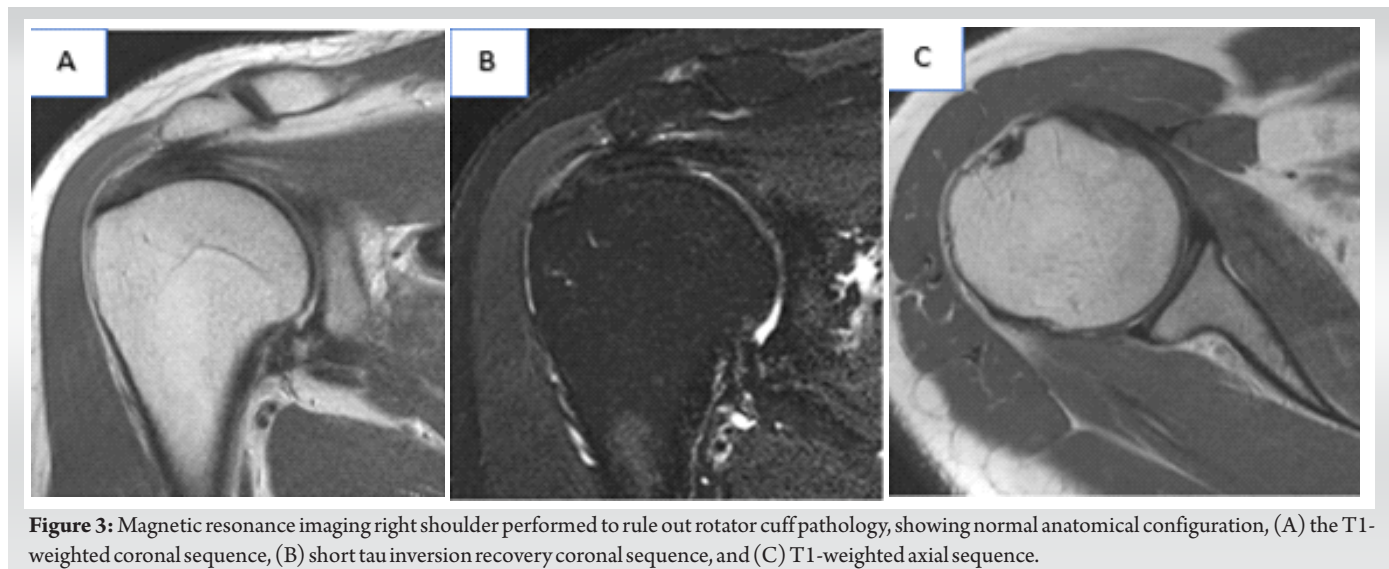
Magnetic resonance imaging right shoulder performed to rule out rotator cuff pathology, showing normal anatomical configuration, (A) the T1-weighted coronal sequence, (B) short tau inversion recovery coronal sequence, and (C) T1-weighted axial sequence.
